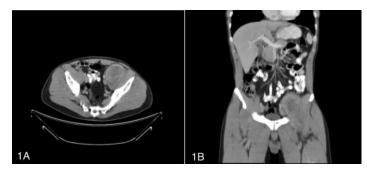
(A) Axial CT scan image shows a mass in the left iliopsoas compartment presenting heterogeneuos contrast uptake predominantly peripheral and central areas without any acquisition that could correspond to necrosis.(B) Coronal CT scan image demonstrating the tumoral extending to the root of the tight
